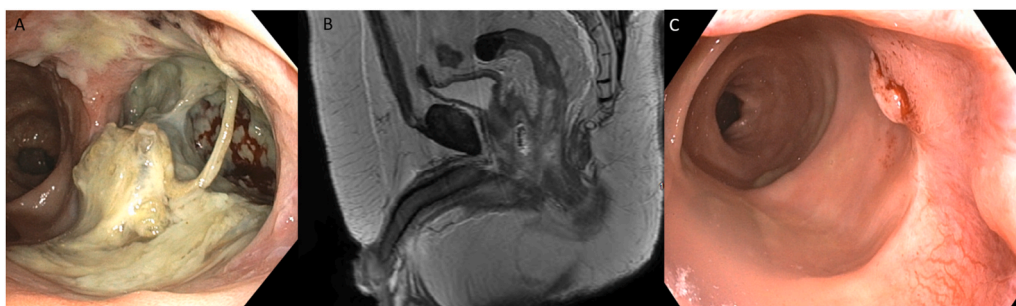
(A) Colonoscopy demonstrates large distal anterior rectal ulceration which was likely secondary to the disruption of the anterior rectal wall with rectourethral fistula. (B) MRI pelvis demonstrates a wide area of communication between the rectum and the prostate after SpaceOAR procedure. (C) Colonoscopy two months after surgery demonstrates well-healed rectal repair with some granulation tissue.
